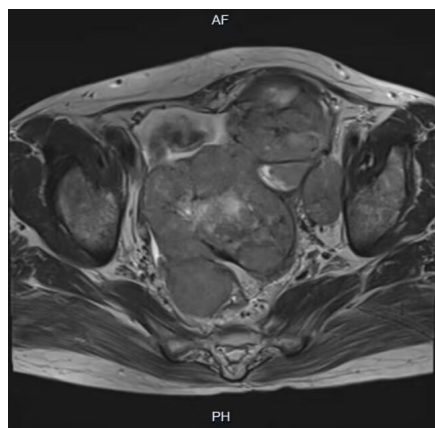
MRI features of ovarian cancer.
